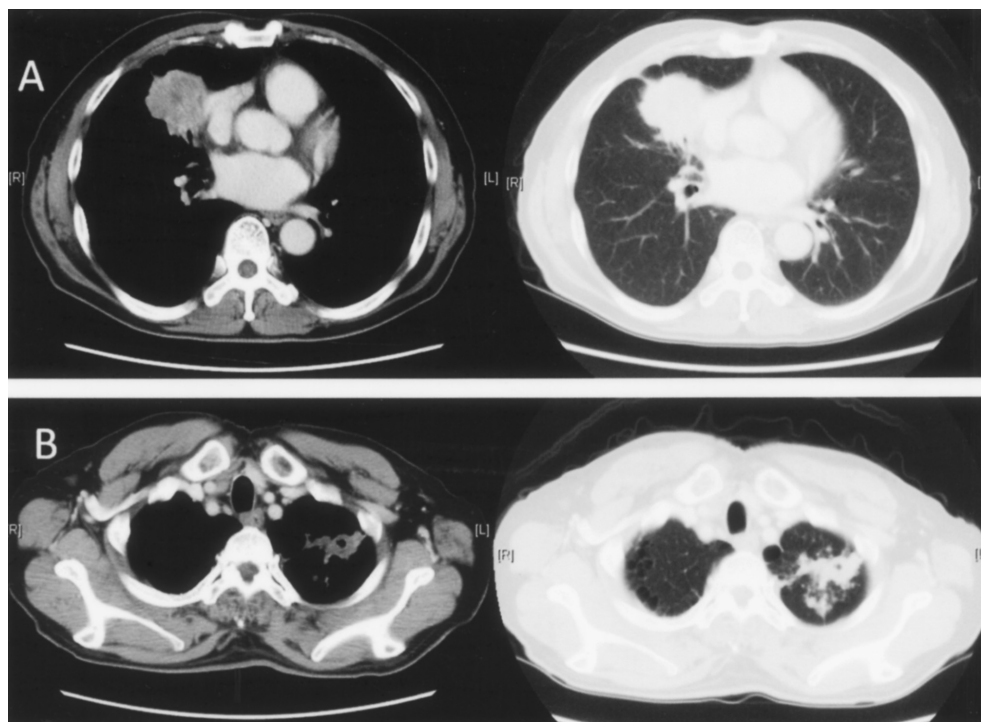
Computed tomography. (A) A 4.5 x 4.6 cm lobulated lung mass in the right middle lobe, adjacent to the pericardium; (B) A cavitary lung mass in the left upper lobe had a variable thick wall and irregular shape. There were some fluffy nodules around the lung mass.
